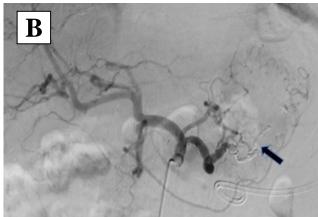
(A) Selective angiographic image during delivery of Histoacryl glue. Tip of microcatheter (black arrow) placed near ostium of lower pole branch. There was reflux of glue to the upper pole branch (white arrow) and main splenic artery (blue arrow). (B) Coeliac angiogram post embolization showed glue cast within the lower pole, upper pole branch and main splenic artery. (C) CT abdomen 3 days post embolisation shows complete resolution of pseudoaneurysm with glue cast within the splenic artery (black arrow). Noted the mid splenic parenchymal infarctions (white arrow).
